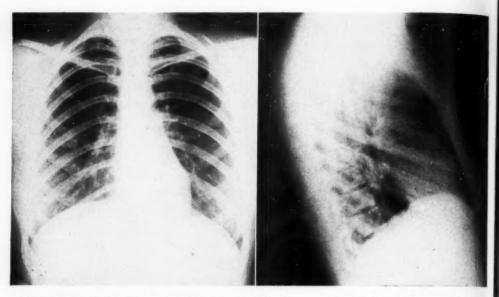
Case 2: R. N., white female, 21 years, nurse. Roentgenograms made in June 1946, a month after discovery of the lesion on a routine chest film. A large nodule is demonstrable. The lateral film shows the lesion to be in the subapical portion of the right lower lobe
